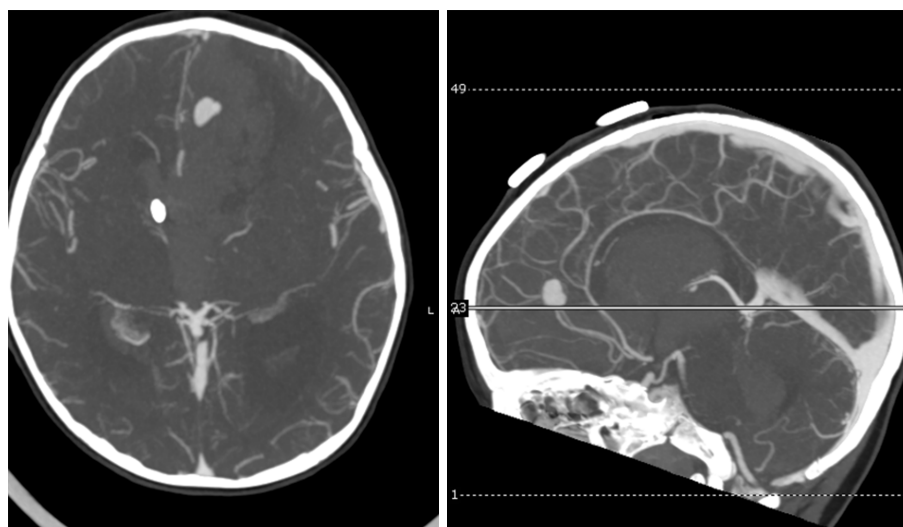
Computed tomography angiography of the head axial (left) and sagittal (right) demonstrated a saccular aneurysm in the inferior frontal region in close association with intraparenchymal hematoma.
